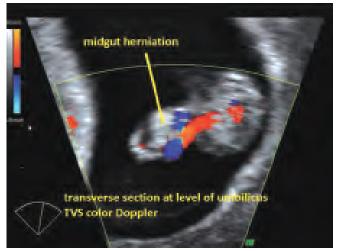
Physiologic umbilical hernia: gray scale color Doppler
